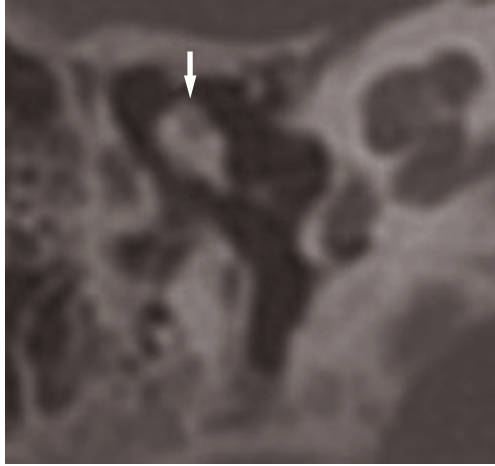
Axial CT scan. Seven-month-old male. Abnormal fusion of the head of the malleus with the body of the incus. Hypodensity due to incomplete ossification of the head of the malleus (arrow), normal at this age.
